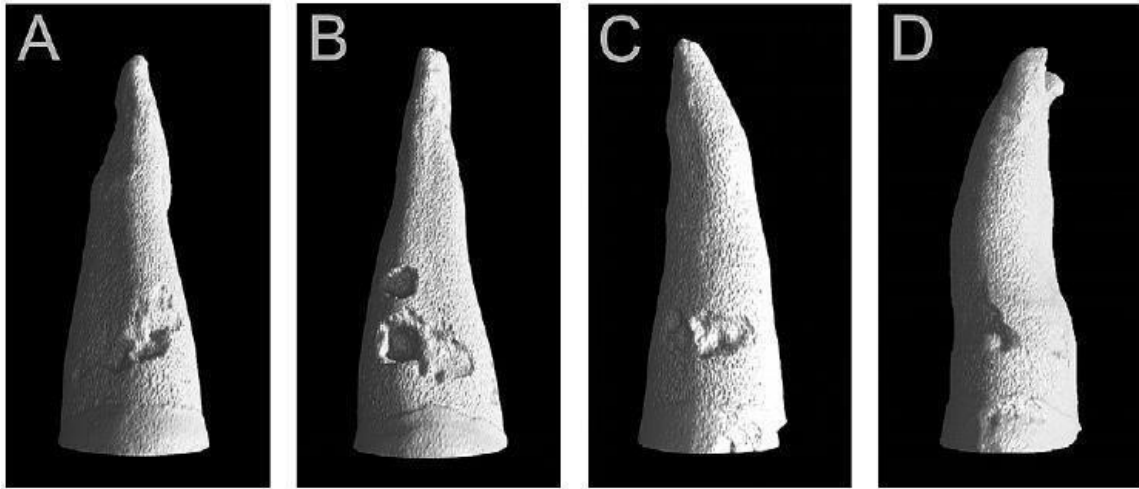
Showing Root resorption using Micro computed tomography (Aras et al., 2011)
